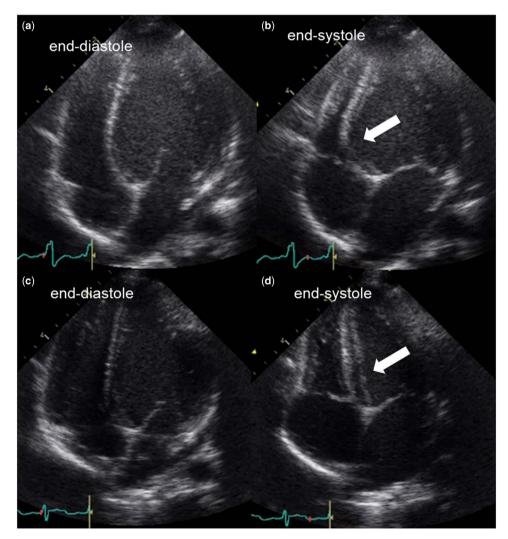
Echocardiographic four-chamber views (a), (b), captured at the first examination. b) Abnormal movement of the basal septum (arrow), similar to an aneurysm at endsystole. (c) and (d) 4 months after flecainide therapy, showing normalisation of septal motion.
